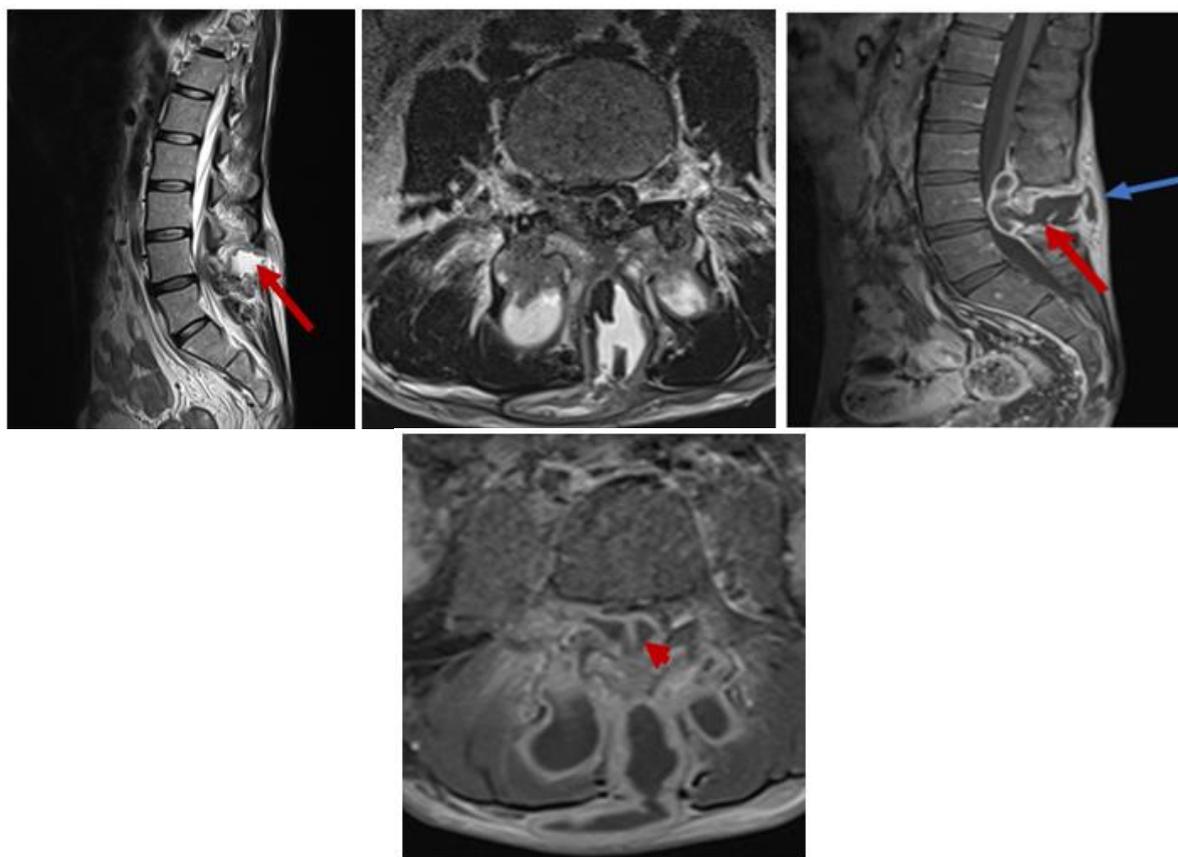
Spinal cord MRI: in gadolinium-injected T1 and T2-weighted axial and sagittal sequences: Lesional process of the posterior arch of the lumbar vertebrae L4 and L5 associated with neighbouring paraspinal collections in T1 hyposignal, T2 heterogeneous hypersignal (red arrow), enhanced in the periphery after injection of gadolinium (arrow) and communicating with other subcutaneous collections in the lumbar region (blue arrow); These collections fused into the posterior extra-dural intracanal space with posterior epiduritis (arrowhead) and bilateral radiculitis responsible for compression of the cauda equina roots
